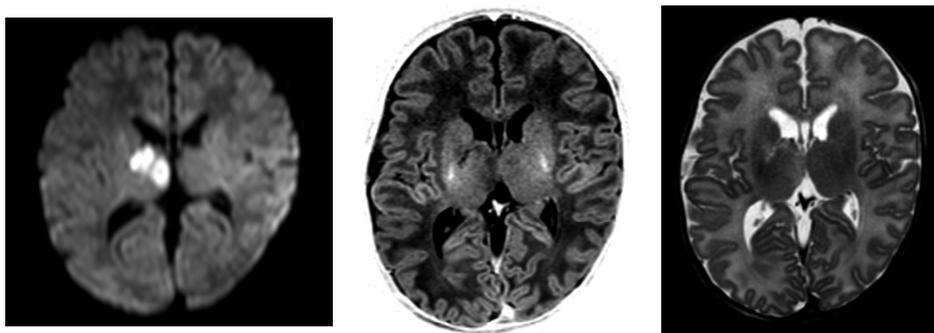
Stroke in the right thalamus and part of the internal capsule, much more apparent on DWI (left image, lesions in white) than on T1 (middle) or T2 (right).
